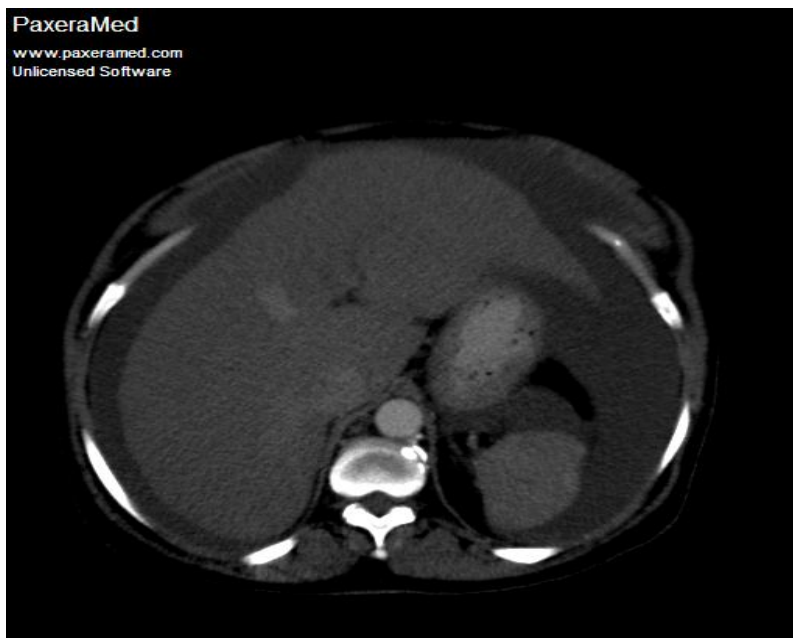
85 yrs Male axial abdominal contrast enhanced CT shown HCC with liver cirrhosis
